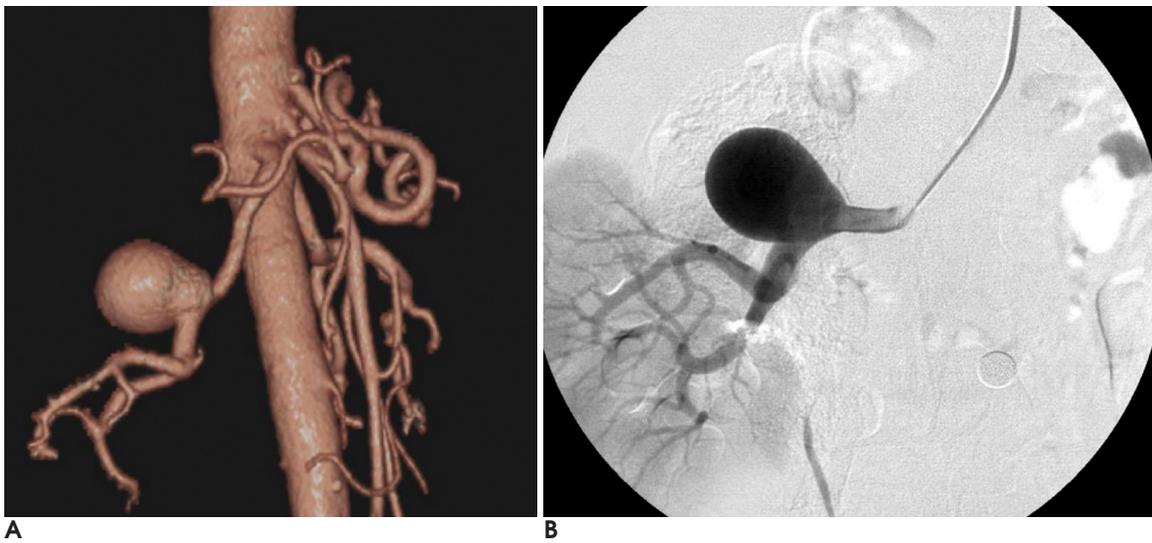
A. CT angiography shows the saccular aneurysm and acute aortorenal angle of right renal artery. B. Selective right renal angiography shows the aneurismal sac with wide neck and mild dilatation of distal portion of renal artery.
